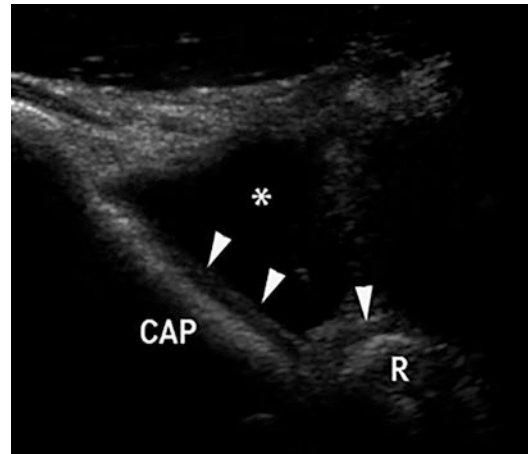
Longitudinal ultrasound view of the lateral elbow showing the articular cartilage (arrowheads) of the capitellum (CAP) and radius (R). Joint fluid is marked with the asterisk
